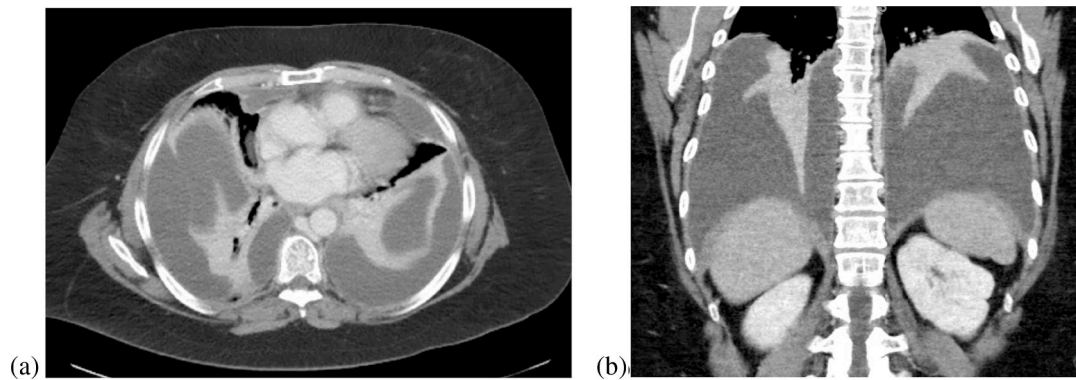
(a)Caption: Representative sections of a CT scan (axial section on the left (a), coronal section on the right (b)) showing bilateral pleural effusions with loculations at the lung bases.
